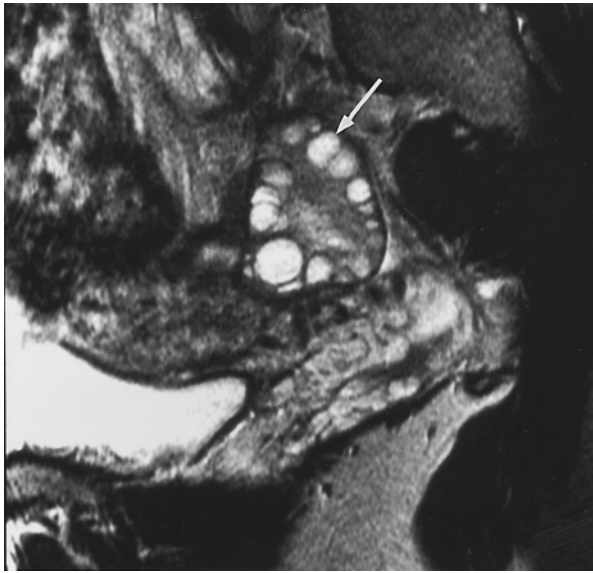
Polycystic ovaries. Sagittal 512-resolution T2-weighted ETSE image demonstrates a mildly enlarged ovary that contains multiple, similar-sized cysts (arrow). Central ovarian tissue is low in signal intensity, reflecting increased medullary cellular stroma.
